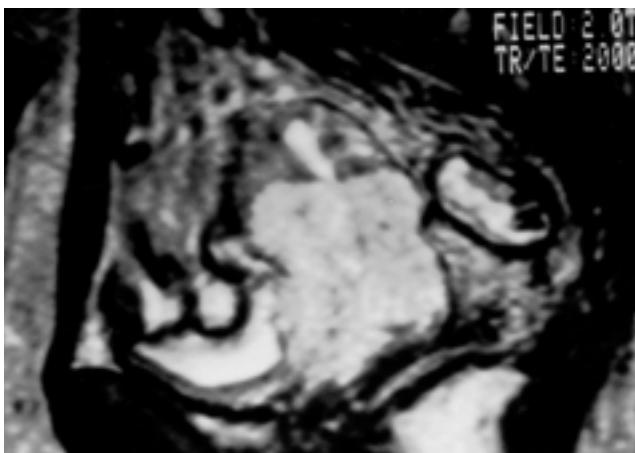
Cervical carcinoma involving whole uterine cervix shows invasion of full-thickness of the uterine corpus on sagittal T2-weighted image.
